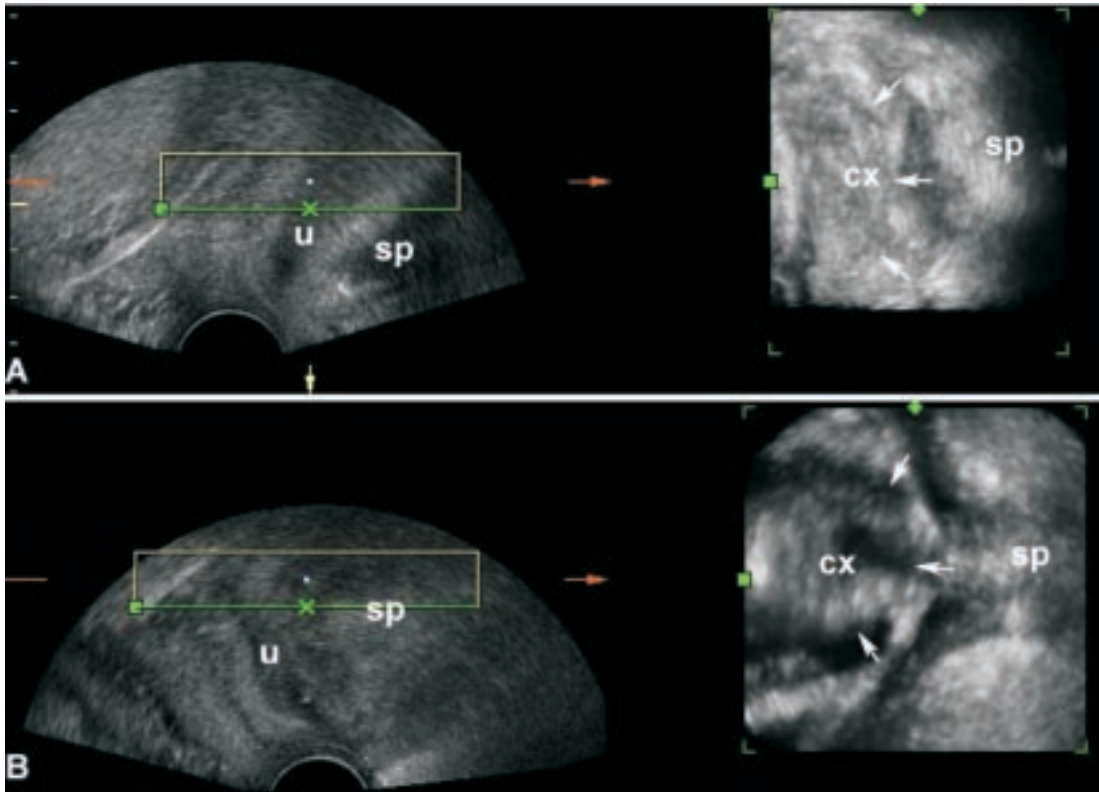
3D ultrasound axial views at rest (A) and during stress (B) demonstrating the lower bladder is compressed posteriorly by the cervix (cx, arrows). There is no urine visible between the cervix and pubic symphysis (sp). The inferior borders of the boxes marked × indicate the level of the section lines in the sagittal views selected for the plane of axial views. (u = urethra)
